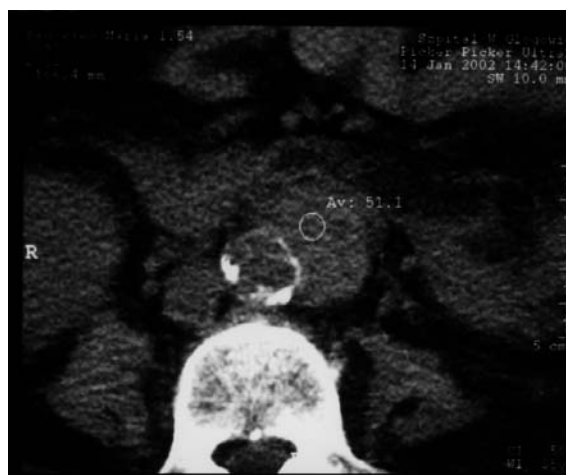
CT of abdominal cavity: cross-section of the abdominal aorta below the renal arteries branching point with effusion space; no contrast
